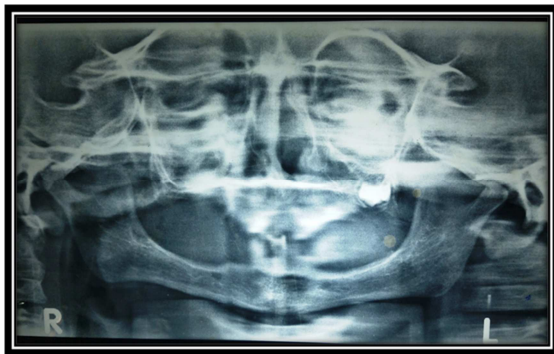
Panoramic radiographic reveals only tooth present 27
